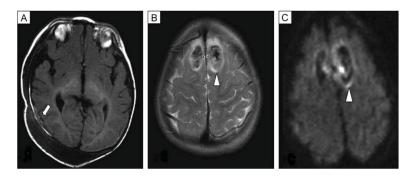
Examples of predominantly traumatic brain injury patterns. A, T1-weighted sequence shows small subdural hemorrhage over the right posterior temporal region (arrow) in a 6-month-old infant with accidental trauma. B, T2-weighted image in a 16-month-old child with inflicted trauma shows two frontal contusions with intraparenchymal hemorrhage (arrowhead), and diffusion weighted image. C, Surrounding rims of restricted diffusion. Reprinted with permission from J Neurotrauma 2007;24:106–18.
